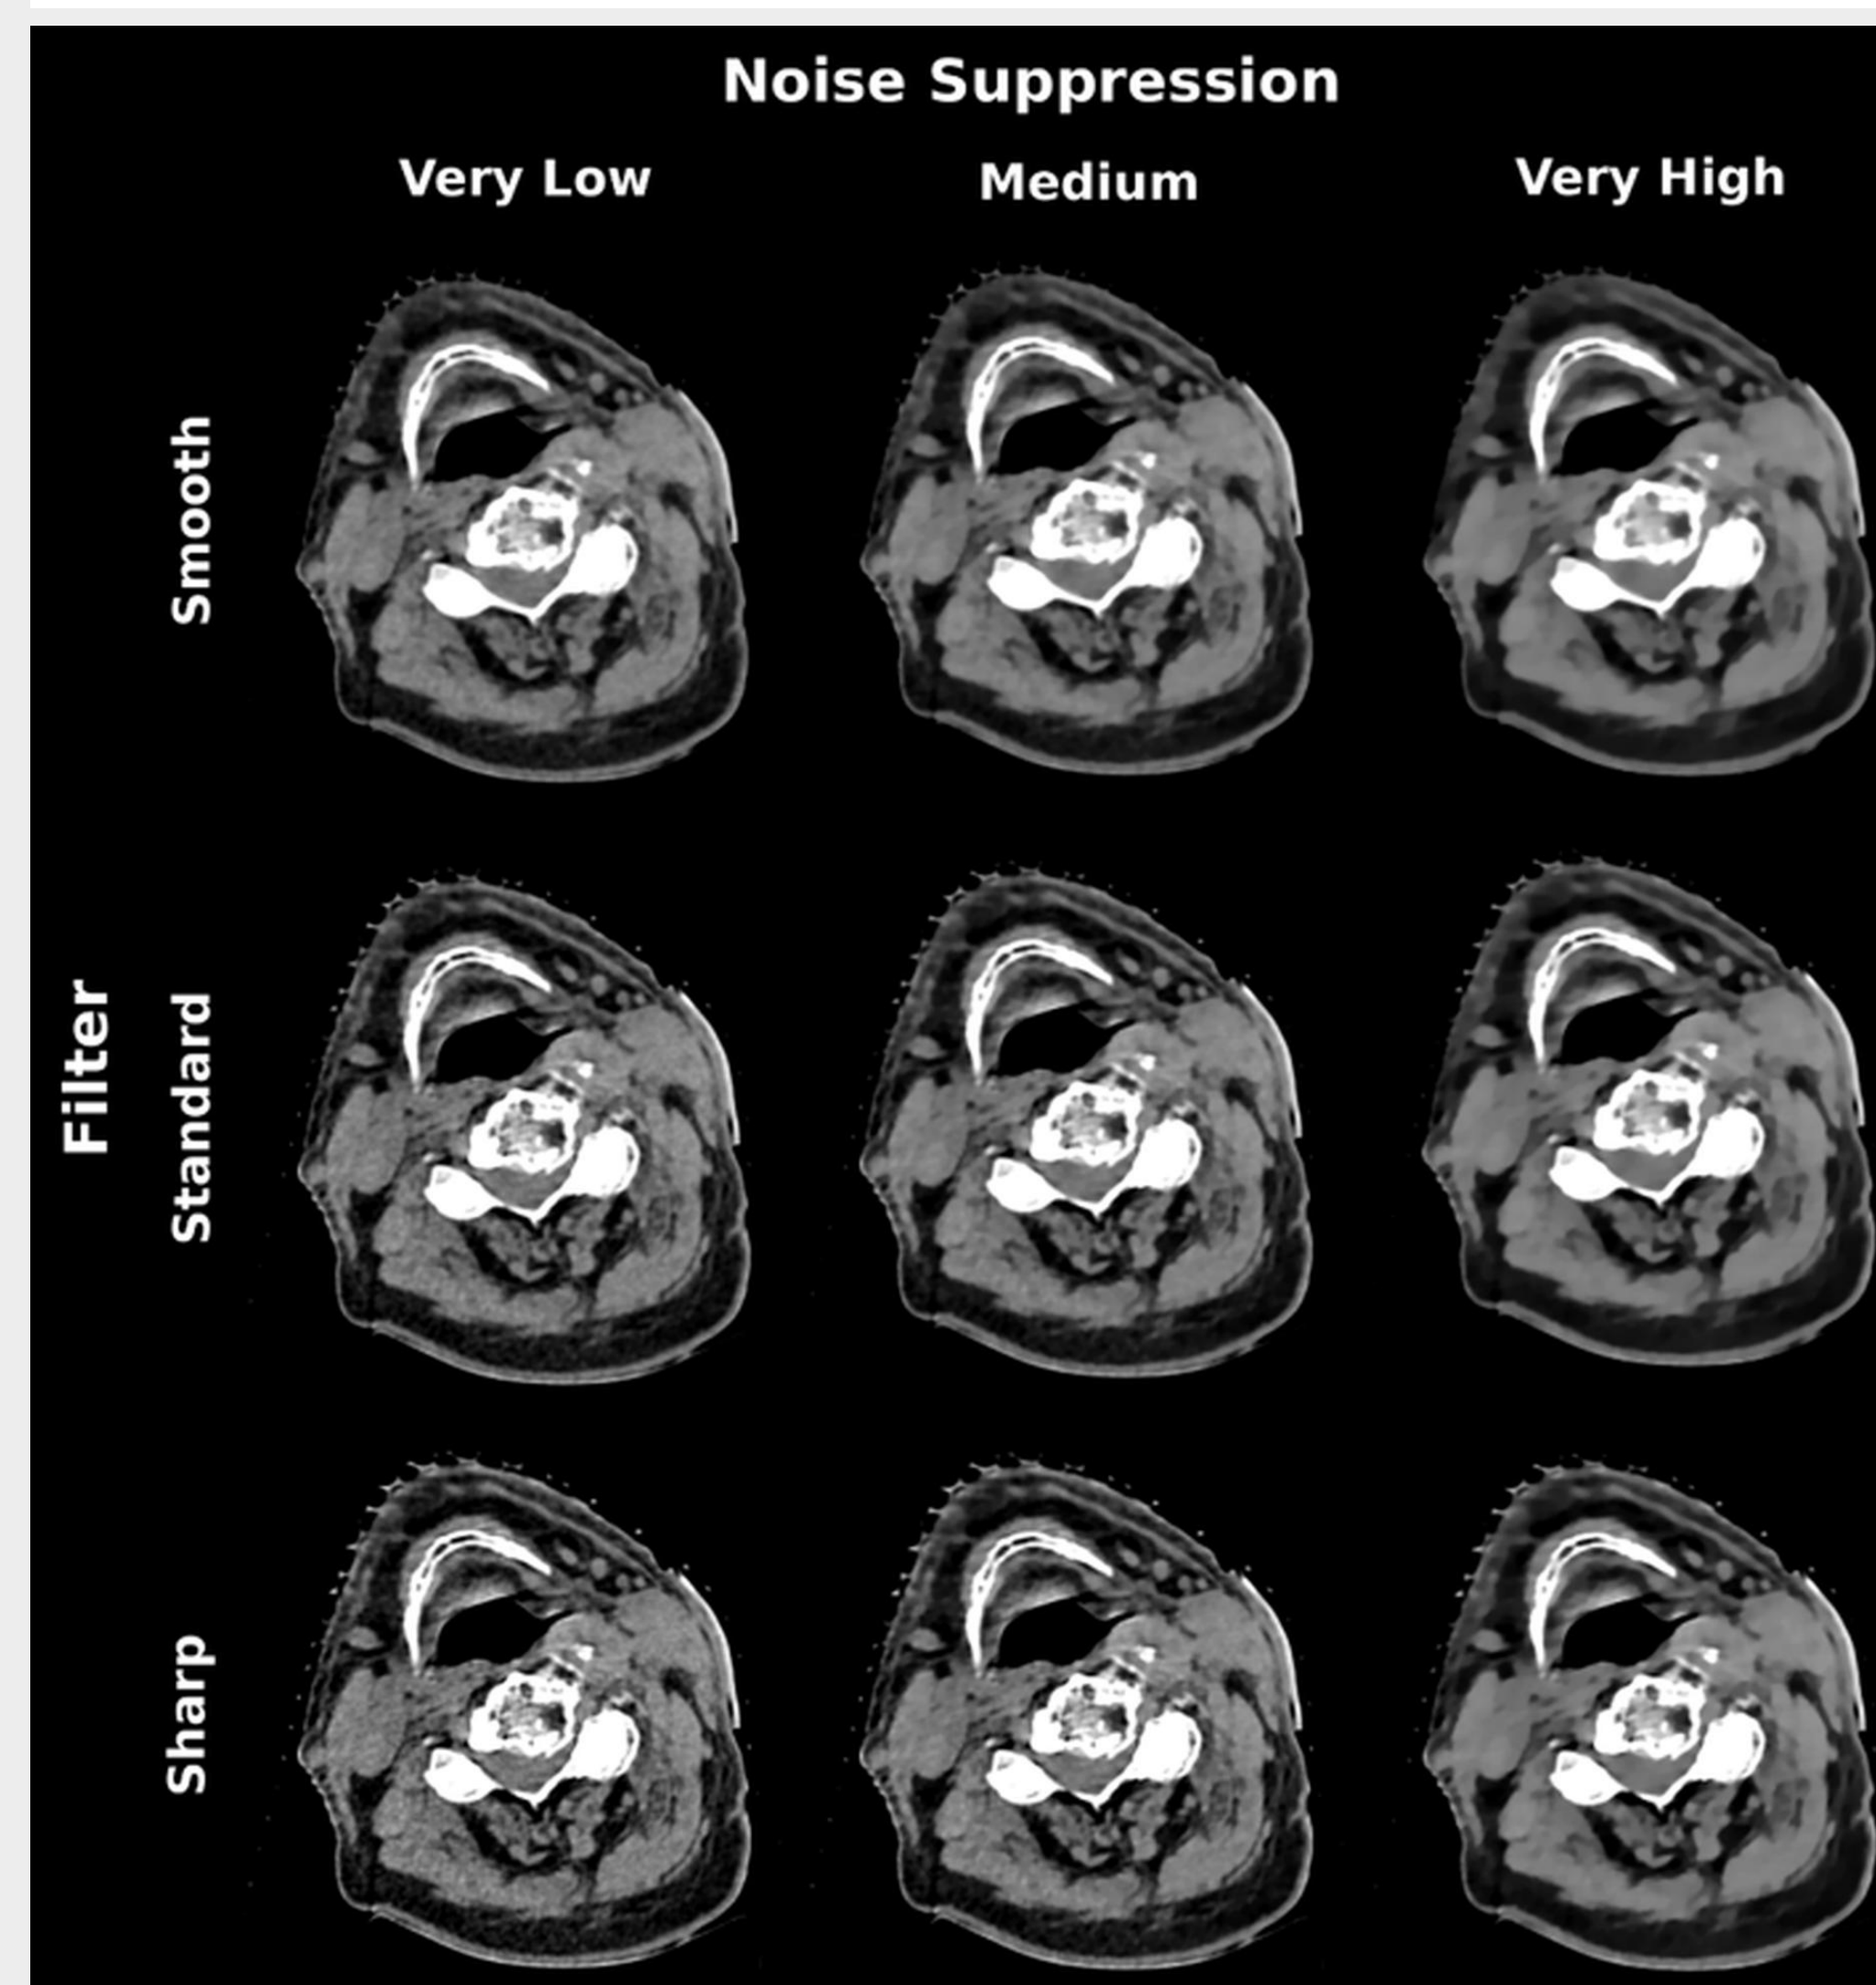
Comparison of each possible iCBCT combination, each reconstructed from a CBCT performed on a head and neck patient with our new C-arm linac imaging panel.
